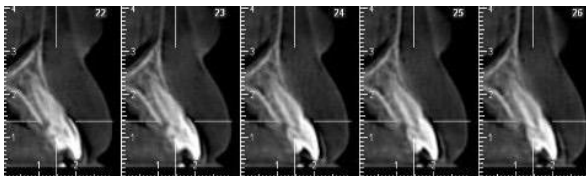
Computed tomography images shows revealing dens invaginatus.
